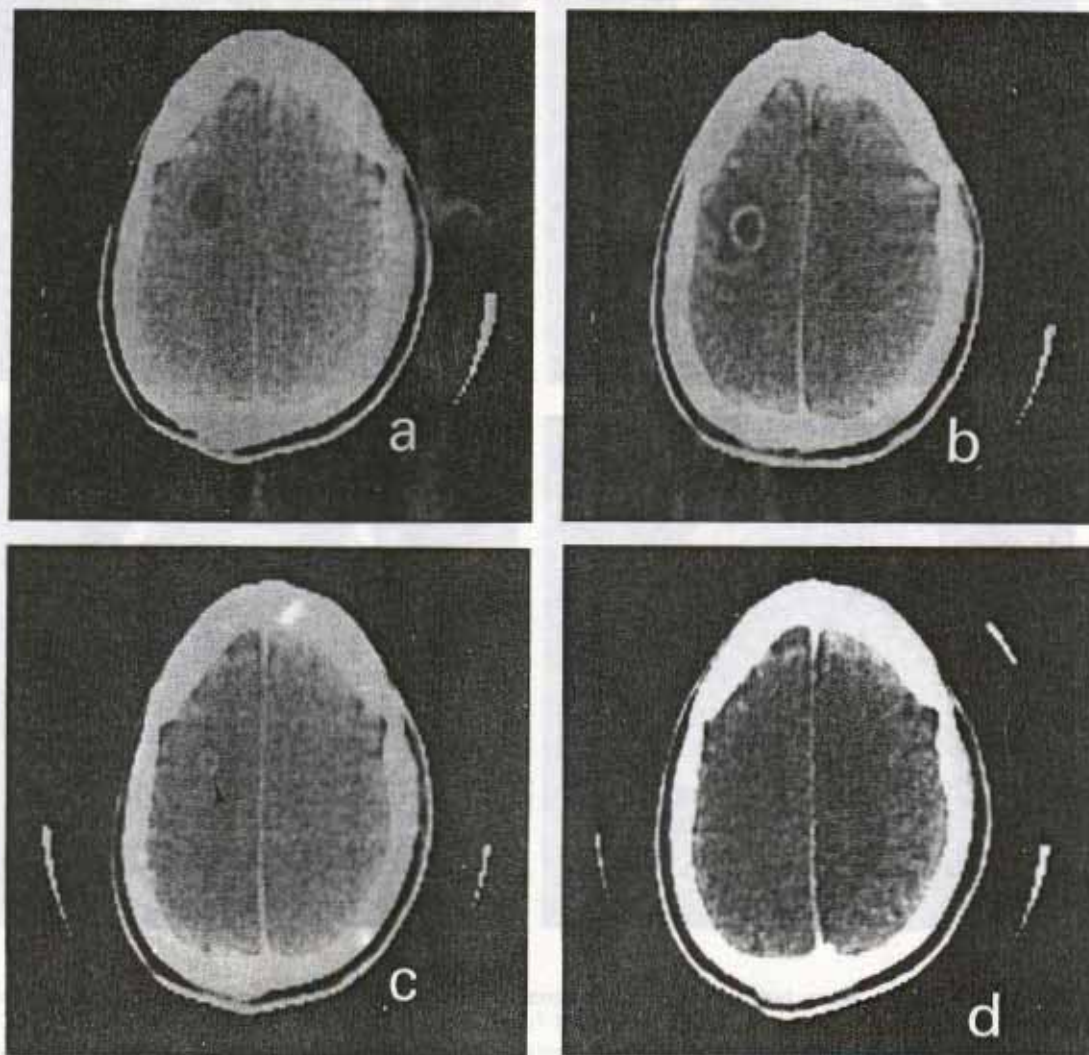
CT Scans Showing the Evolution of Cysticercosis in Patient 13 (Table 1) after Treatment.
